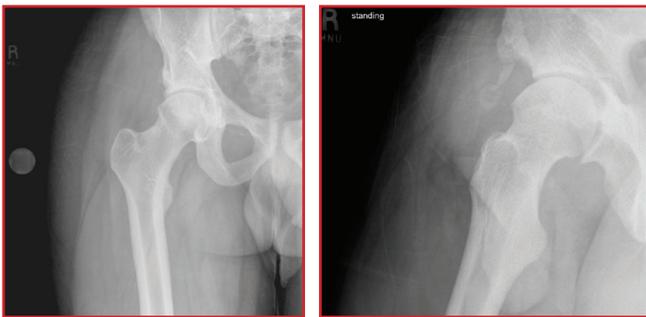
Plain x-rays of right hip, post-operative
